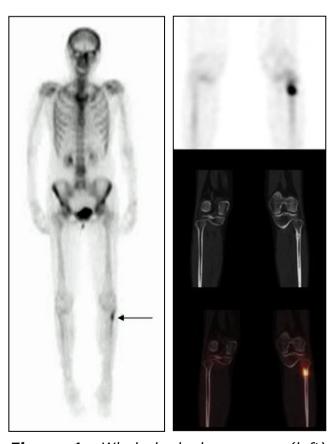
Whole-body bone scan (left) showing a discrete focus of increased uptake below the left knee laterally (arrow). SPECT-CT images (right) showing focal increased activity to correspond to a fibular fracture
